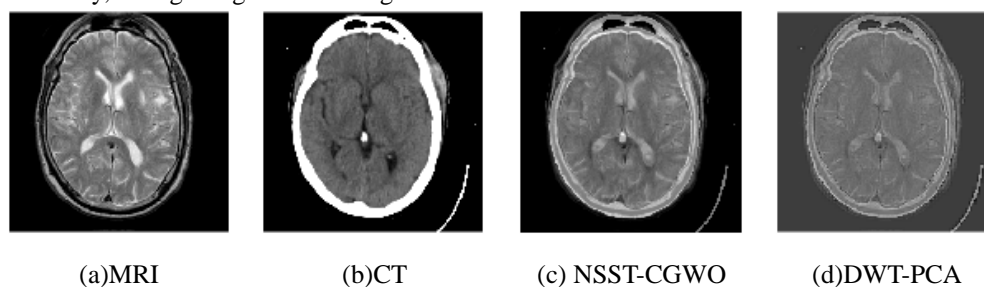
Qualitative outcomes of fatal stroke (CT-MRI-T1)
